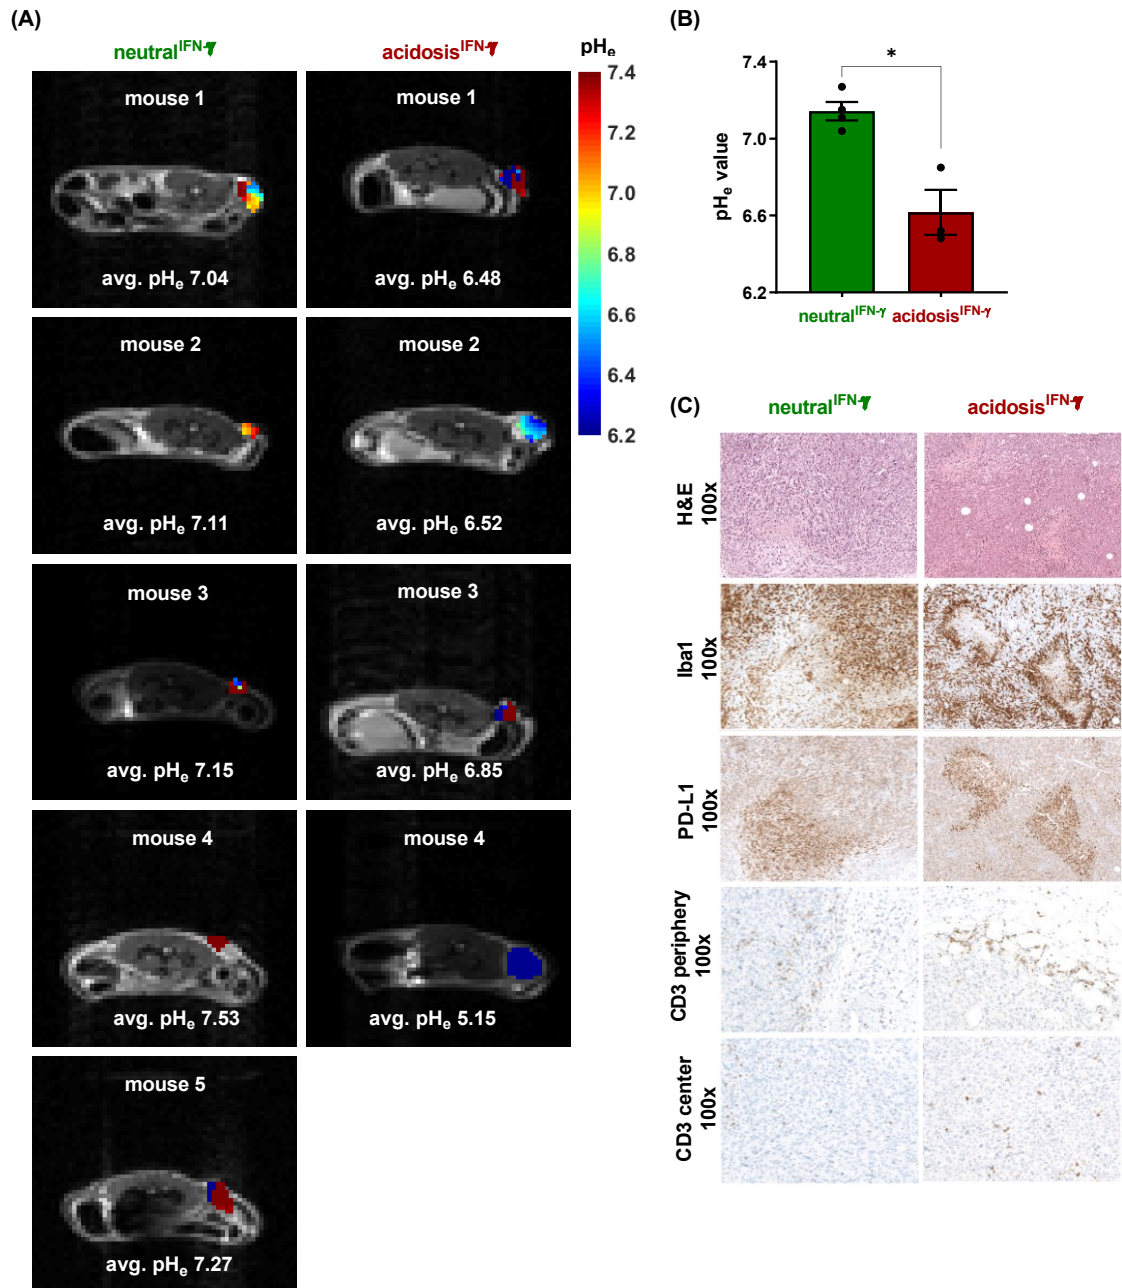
Imaging of tumor pH_e neutralization via sodium bicarbonate treatment using non-invasive *in vivo* acidoCEST-MRI.
